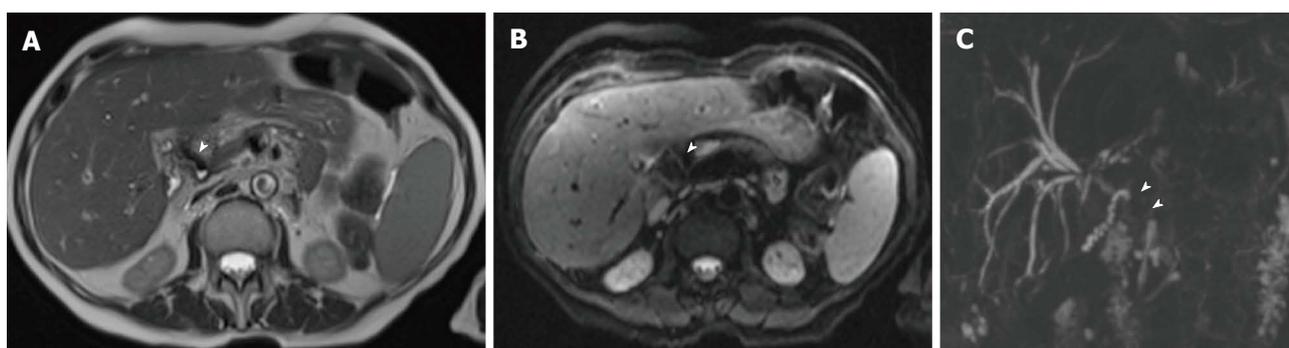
Aerobilia in a 62-year-old female patient transplanted for alcoholic cirrhosis. Anintense filling defect in the common bile duct on T2-weighted axial HASTE image (arrowhead in A) is associated to distortion artifact on axial Diffusion-weighted sequence (arrowhead in B). The effect of pneumobilia was to extensively mask the common bile duct on 3D magnetic resonance cholangiography (arrowheads in C).
